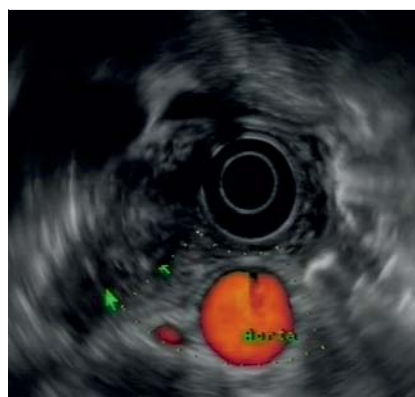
Follow-up endoscopic ultrasound (EUS) image 6 weeks later showing complete resolution of the lesion.
